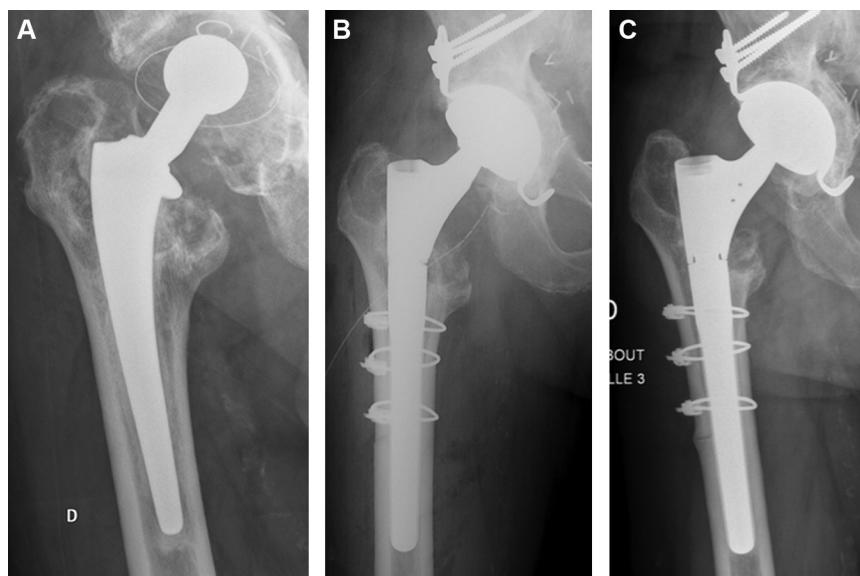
Example of global fit in case No. 3. A. Indication for cup and stem revision in an 88-year-old patient. B. Postoperative radiographs with global fit. C. Review after 62 months with good osteointegration and secondary stability (moderate osteolysis in Gruen zone 2 and absence of periprosthetic radiolucent lines).
